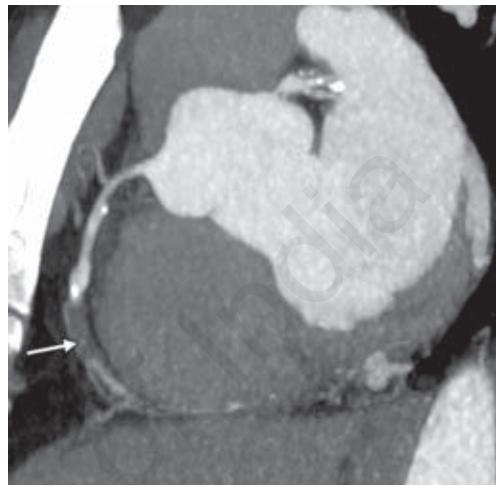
Computed tomography angiography image showing complete occlusion of mid right coronary artery (arrow) with calcific plaques in proximal and mid-part.
